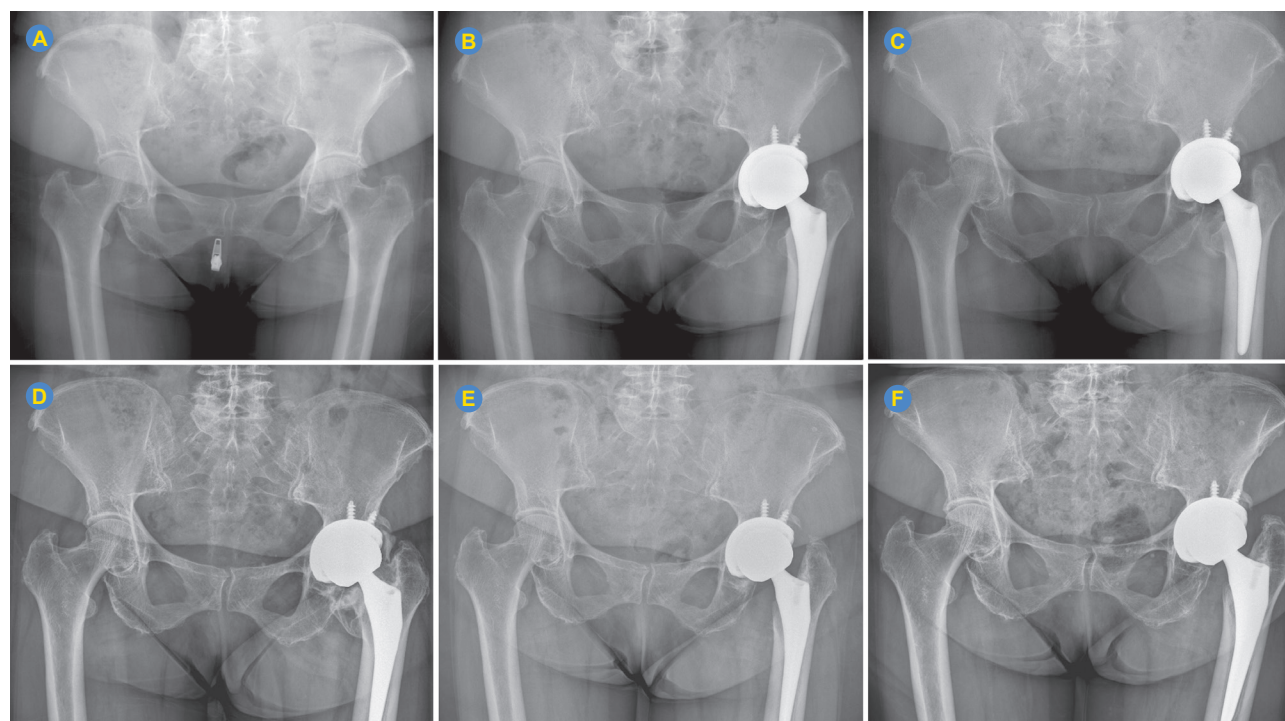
Radiographic evolution: pelvis antero-posterior radiographs of the patient in different treatment phases; (A) Presentation with left hip osteoarthritis; (B) Post-operative control after total left hip arthroplasty; (C) Three months after THA, HO Brooker Grade II; (D) One year after THA, HO Brooker Grade IV; (E) One month after HO excision and RT; (F) Two years after HO treatment.
